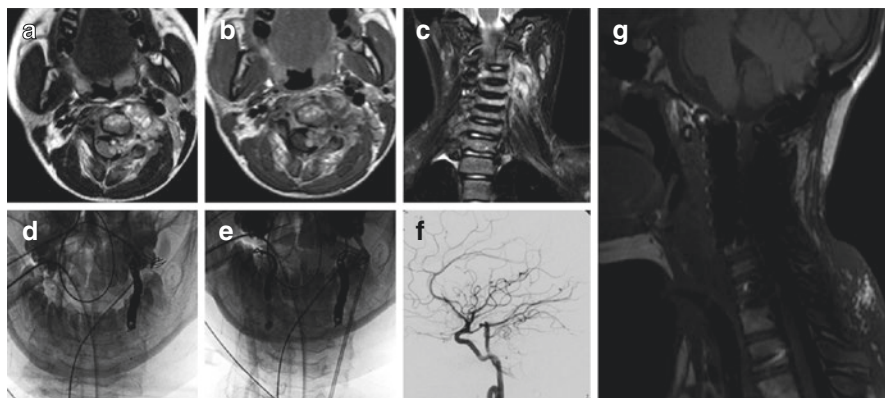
Thirteen-year-old girl with an osteosarcoma of C2-C3 extending to the paraspinal soft tissues as shown in the MR images (a, b, c). The patient undergoes a preoperative endovascular occlusion of both vertebral arteries (d, e) after performing an occlusion test in order to evaluate the collateral supply from anterior circulation. Right internal carotid selective angiogram (f), acquired after occlusion of both vertebral arteries, demonstrates a good supply of the posterior circulation via the posterior communicating artery. Sagittal MR image shows the result of the reconstructive surgery (g)
